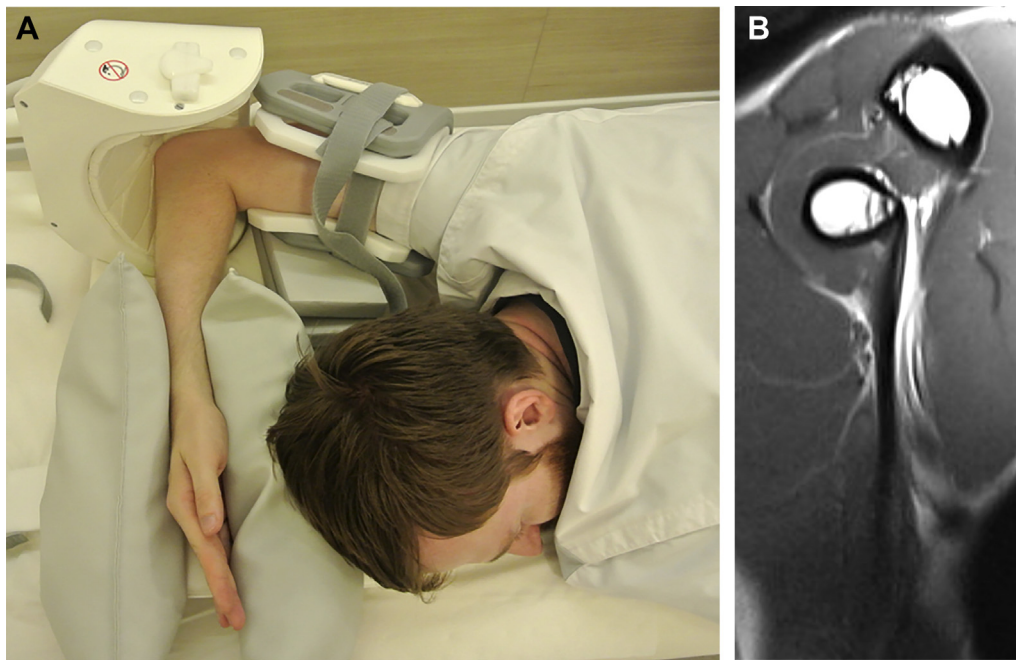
(A) Flexion-abduction-supination-view positioning with shoulder abduction and elbow flexion-supination. (B) Flexion-abduction-supination magnetic resonance imaging view (3-dimensional double-echo steady state with water excitation) showing normal distal biceps tendon. The entire tendon can be viewed from the insertion to the musculotendinous junction on a single image. Courtesy of MoRe Foundation.
